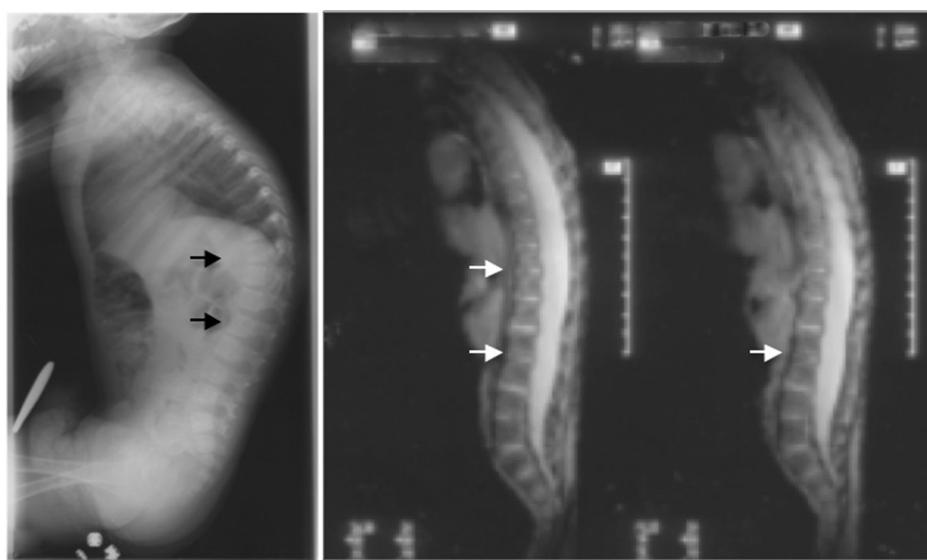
(Left) Lateral whole spine radiograph at 12 months of age, demonstrating loss of anterior disc space height and end-plate irregularity at the T11–T12 and L2–L3 levels (black arrows). (Right) Sagittal short tau inversion recovery magnetic resonance imaging at 12 months of age of the thoracolumbar spine showing symmetrical disc space narrowing (white arrows). The high signal intensity horizontally at multiple end-plate levels was considered a normal physal appearance at this age.
